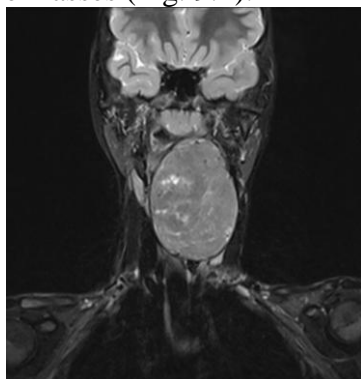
MRI; neurogenic neck tumor (arrow).
